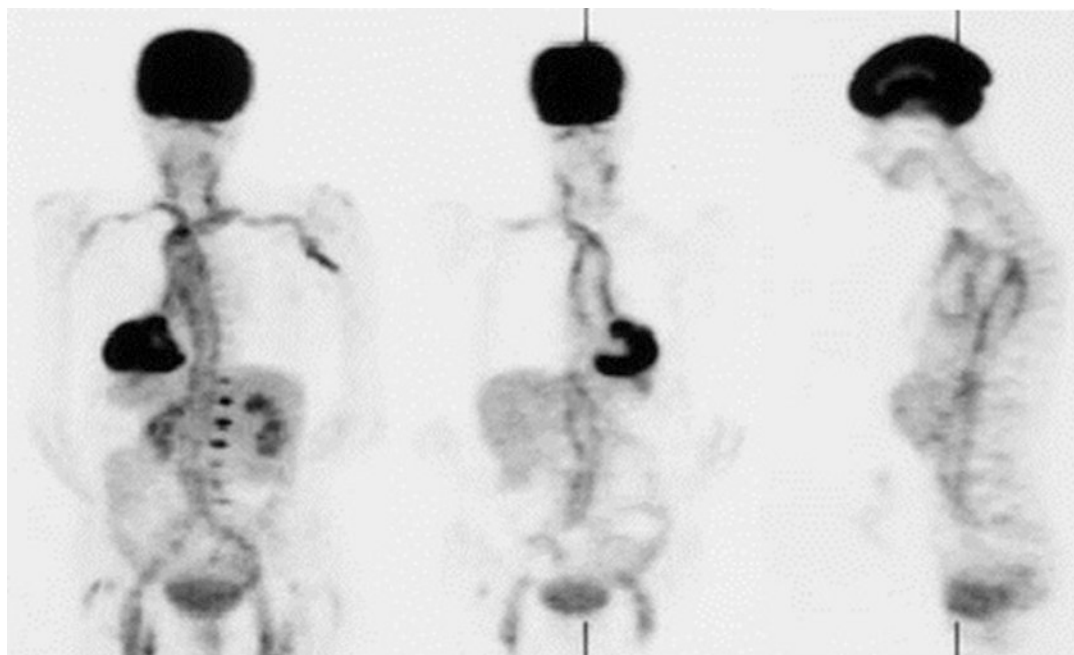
Example of increased ¹⁸F-FDG uptake in the great vessels in a patient with giant cell arteritis. Similar ¹⁸F-FDG uptake is seen in patients with Takayasu arteritis, though usually less extensive (Adopted from Meller et al. [175], Figure 2)
